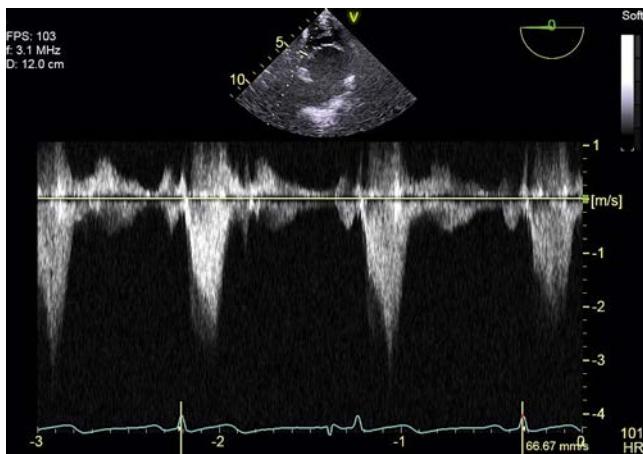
A continuous wave Doppler signal characteristic of left ventricular outflow tract obstruction. The signal appears “dagger-shaped,” with the peak velocity occurring in mid-to-late systole. In the perioperative setting, obstruction may be dynamic and unmasked by precipitating factors in susceptible individuals.
